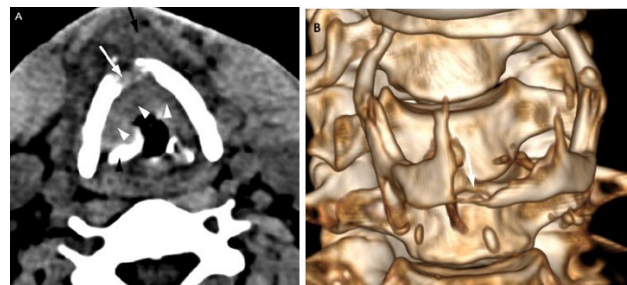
(A, B) CT and 3D reconstructed imaging of glottic carcinoma with cartilage and soft tissue invasion.
